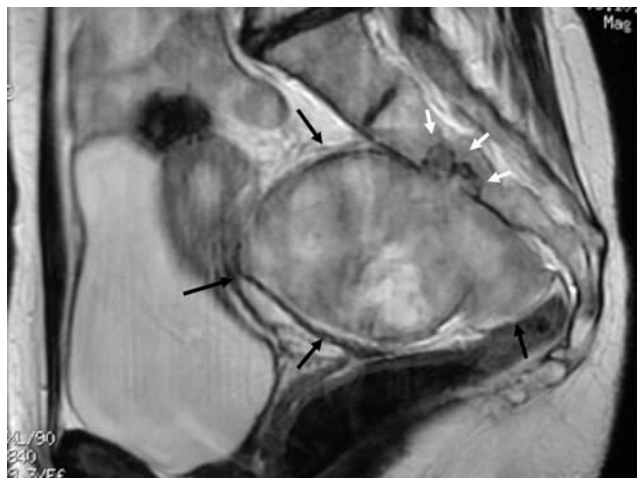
Magnetic resonance image of a schwannoma (black arrows), with sacral involvement (white arrows).
